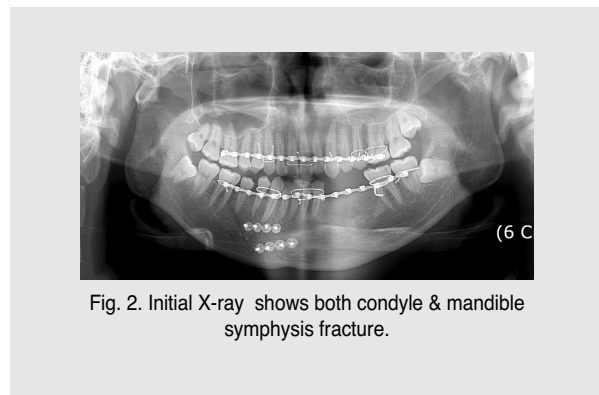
Initial X-ray shows both condyle & mandible symphysis fracture.
